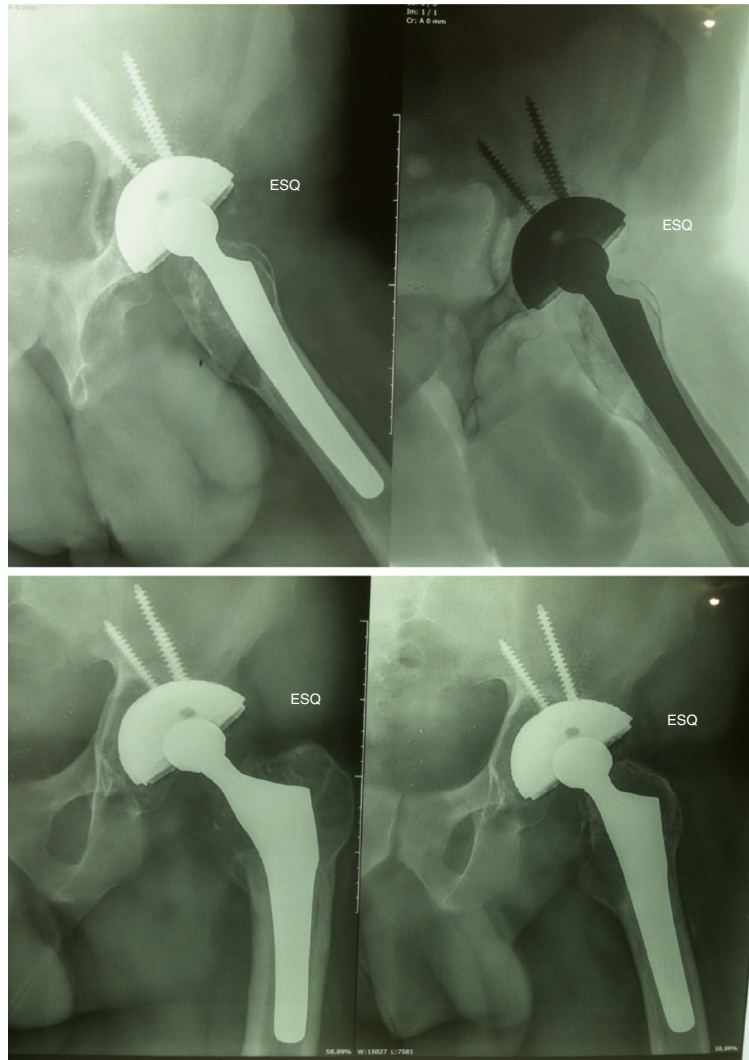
Postoperative control radiographs in anteroposterior and lateral views, produced eight months after revision of the left-side total hip arthroplasty.
